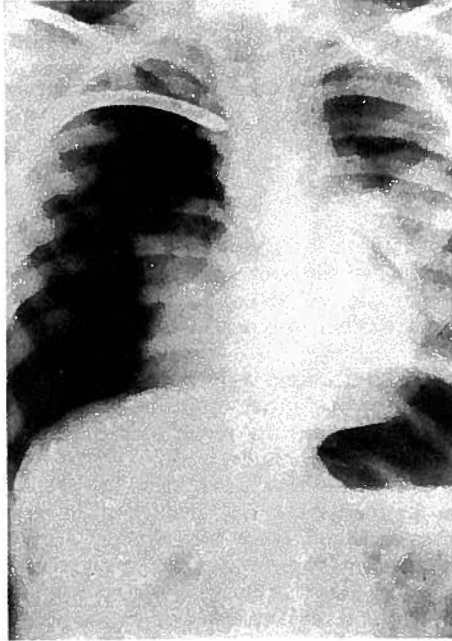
Chest roentgenogram of the boy who aspirated a sharp tack, seen lying in his left mainstem bronchus. The tack first lacerated the membranous portion of the right bronchus and produced a right tension pneumothorax. The boy then coughed it into the left bronchus (see text).
